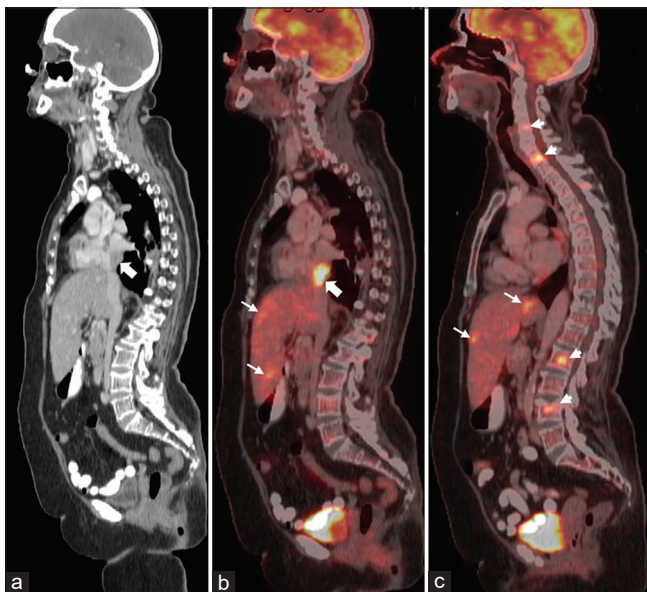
(a-c) Sagittal whole-body computed tomography (CT) and positron emission tomography/CT fusion images show hypermetabolic lesion in the suprahepatic inferior vena cava and right atrium (thick arrow), metastases in liver (arrows) and spine (arrow heads)
